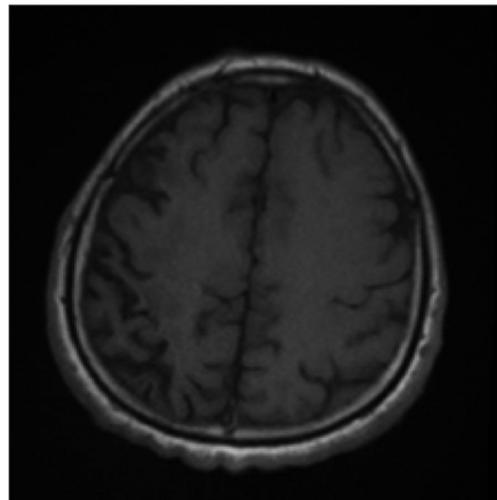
Unidentified bright objects (UBOs) were seen isointense on axial non-contrast T1-weighted MRI.
